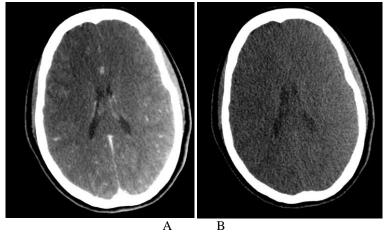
Computed tomography examination. A and B: The results of brain CT angiography showing no obvious abnormality
